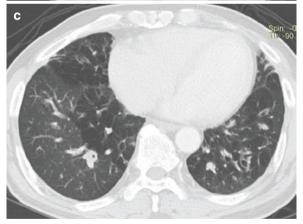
A 59-year-old man with bronchiectasis in lower lungs. (a) Frontal chest radiograph shows linear streaky densities in right lower zone with "tram-track" appearance (arrows). (b, c) Axial CT images show bronchiectasis, bronchial wall thickening, and mucus plugging in bilateral lower lungs
